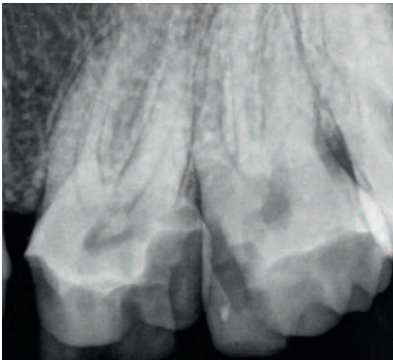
Radiographic examination after caries removal confirming the close proximity of the cavity walls to the pulp chamber
